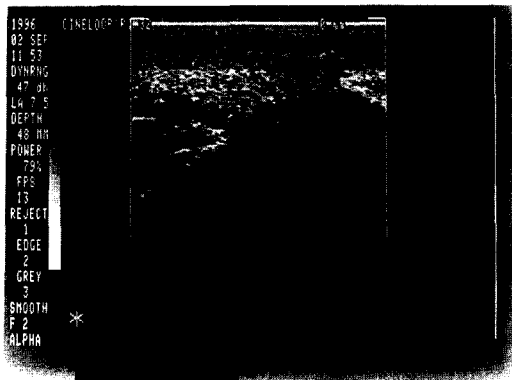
Ultrasonography of parotid gland on heat-sensitive paper
